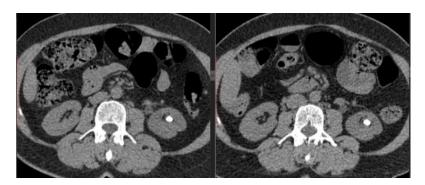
(A, B): CT of the urinary tract revealed left renal lower calyceal stone. (a) Stone appeared by standard dose Computed tomography (120 kV, 420 mAs). (b) The same stone appeared by low dose computed tomography (80 kV, 130 mAs)
